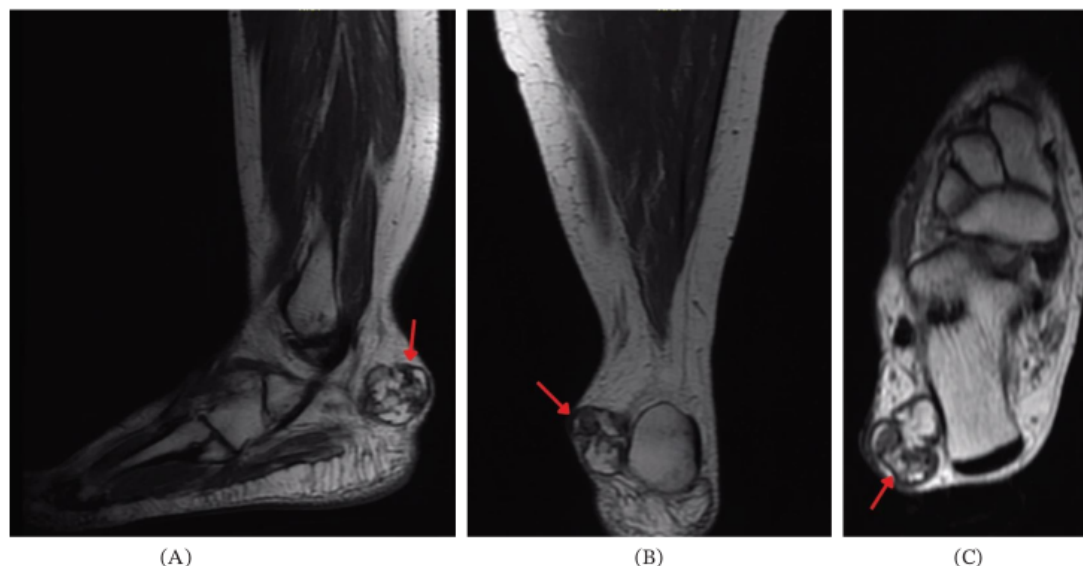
Magnetic resonance images of the right foot in (A) a sagittal, (B) a coronal, and (C) a transverse axial view show a lobulated, septated soft tissue mass with calcification.
